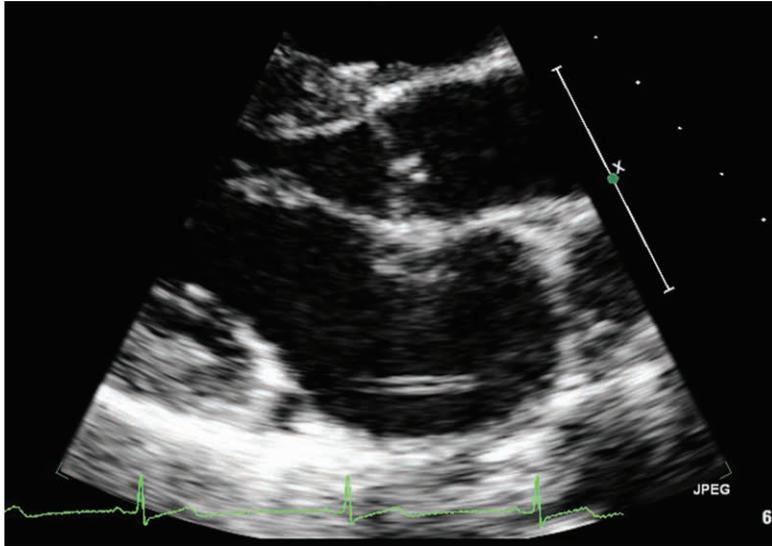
Parasternal long-axis view demonstrating parallel linear densities in the mid-left atrium.
